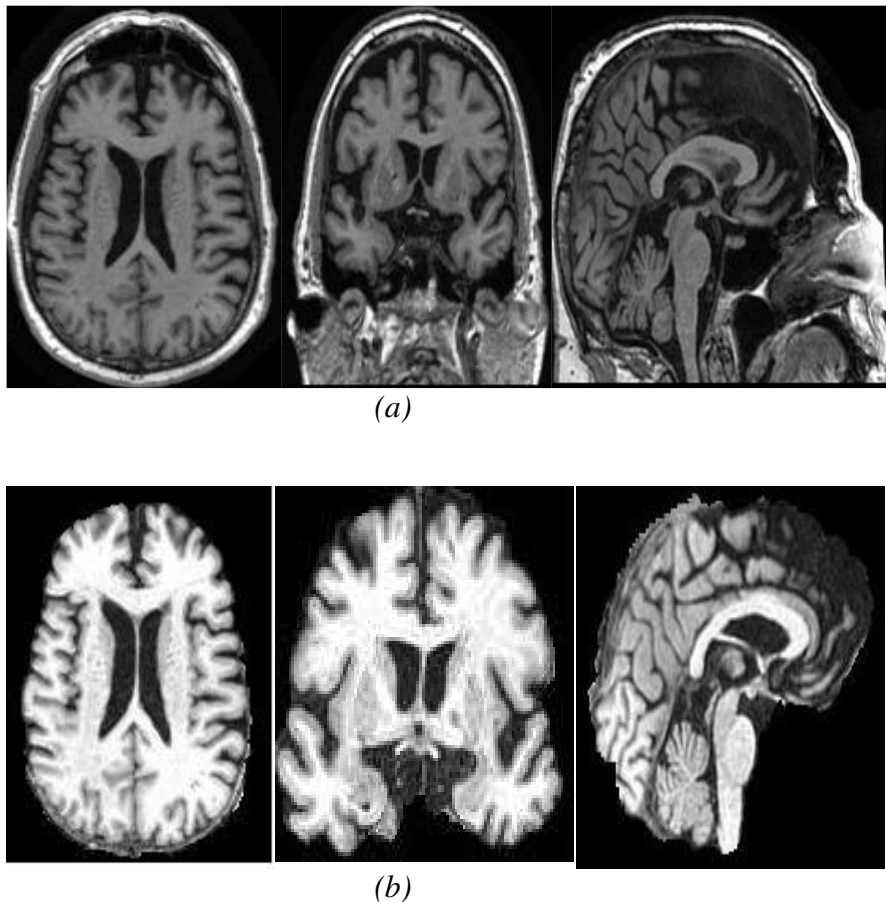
(a) Slices from a single MR image before brain extraction (b) After brain extraction
